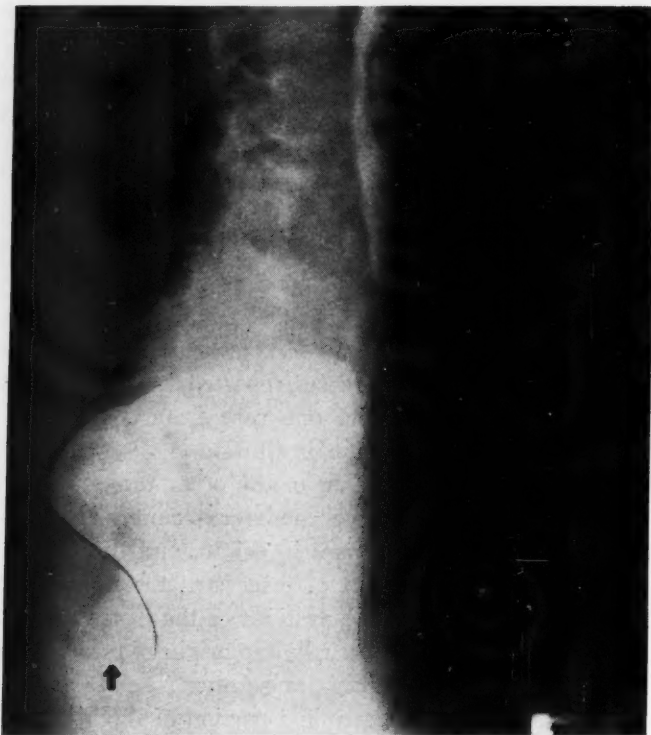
Lateral roentgenograms following barium enema. Anterior border of the tumor has been outlined on the film. (All photographs are by the Army Signal Corps.)
